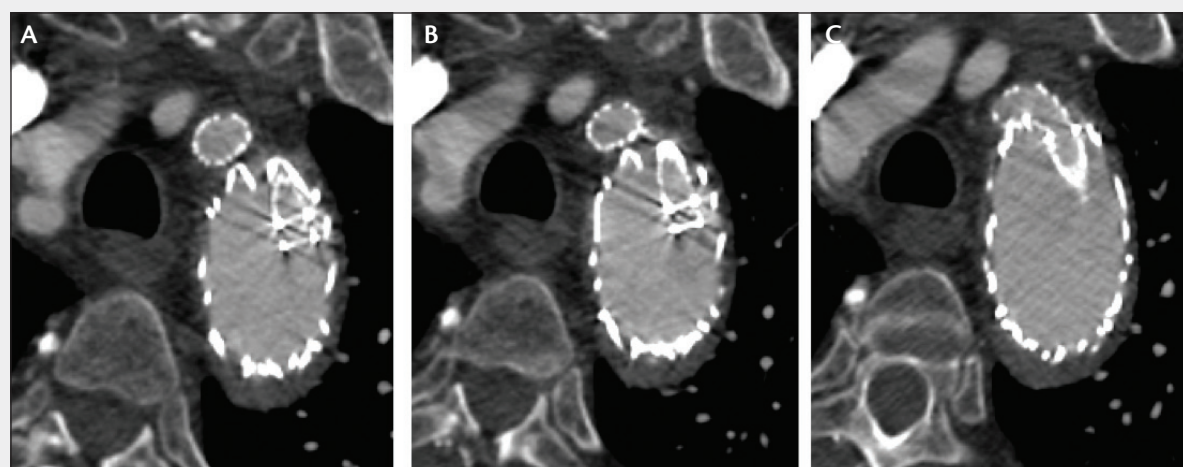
Postoperative CT axial slices of the GORE TAG Thoracic Branch Device focusing on the side branch.
